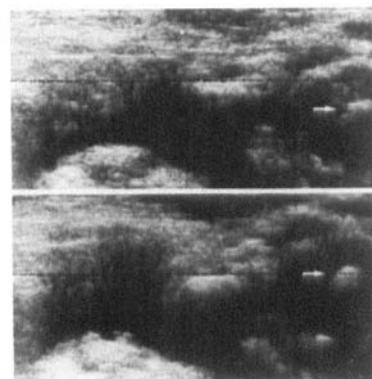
Ultrasonogram of the dislocated femoral head with the hip extended. A dotted line is drawn between the anterior surfaces of the pubic bones. The lower picture was obtained when the baby tried to bend its hip with the joint held in the extended position. The femoral head displaces more anteriorly.
